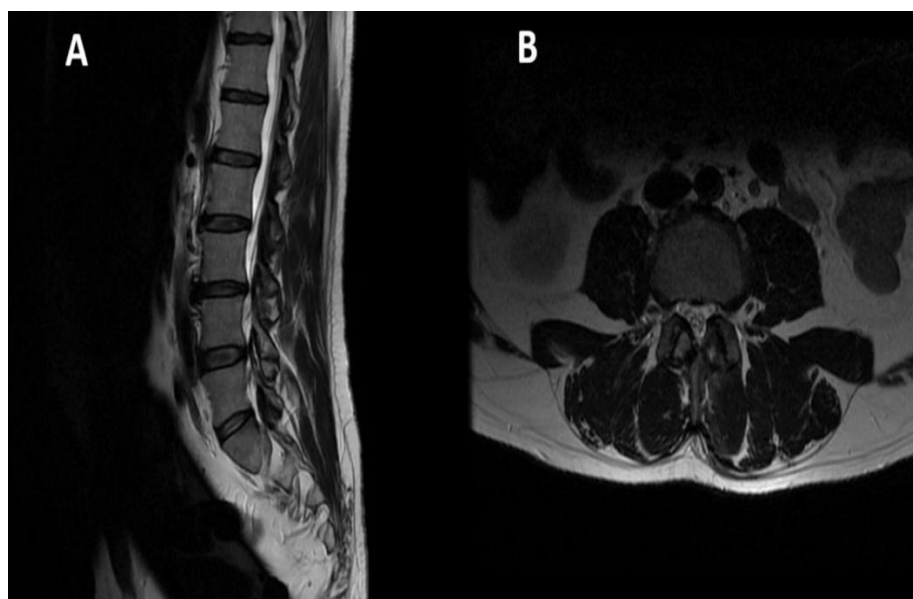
Preoperative lumbar MRI showing L3/L4 disc extrusion.
